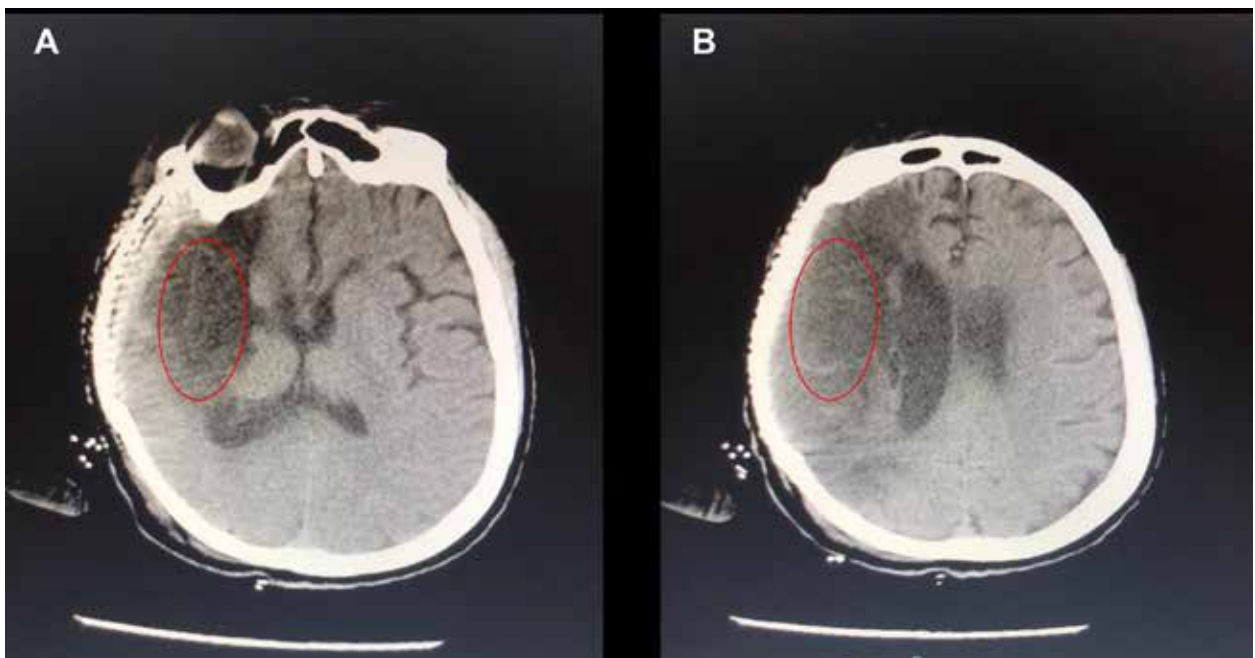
CT images of 60-year-old female with cerebral infarction three months after onset.
